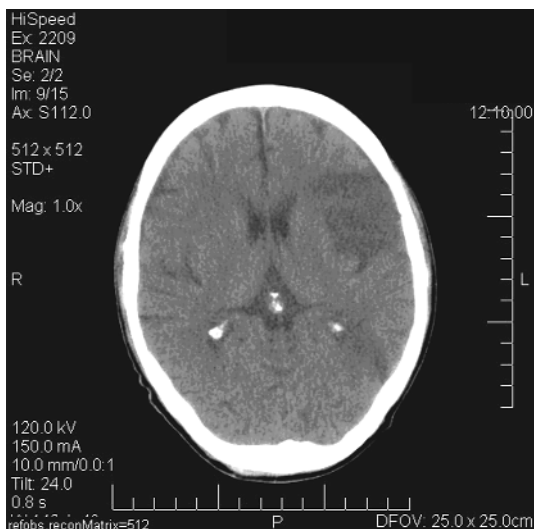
CT-scanning of the patient showing hypodensity in parietal lobe
